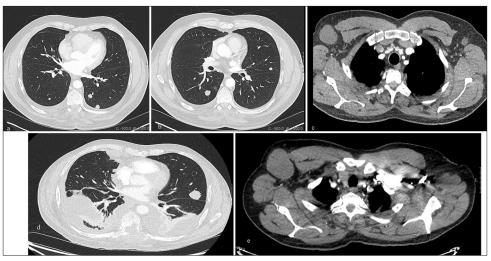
Axial computed tomography (CT) slices at initial metastatic presentation demonstrating (a and b) metastatic bilateral pulmonary nodules and (c) enlarged axillary nodes. Axial CT slices 1 year later demonstrating (d) progression of disease with extensive thoracic metastatic disease, bilateral pleural effusions and (e) further enlargement of axillary nodes.
